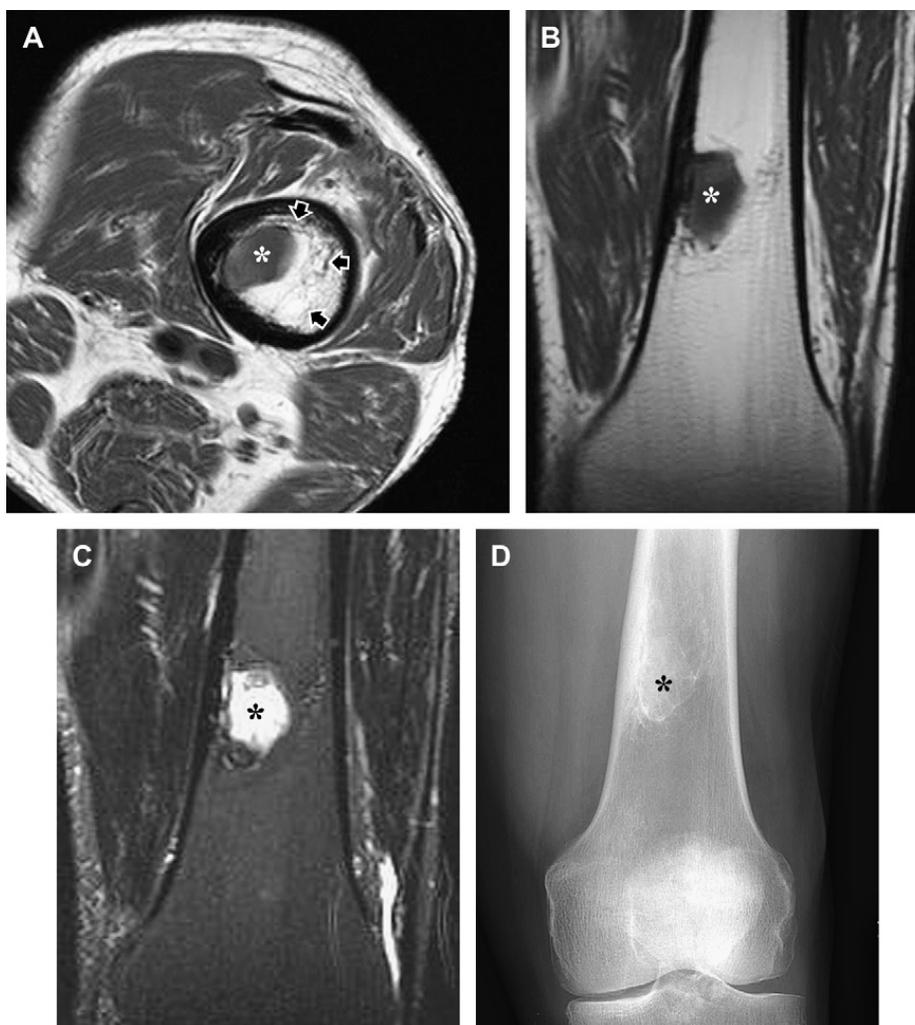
Intraosseous lipoma with involutinal change in the distal femur of a 72-year-old woman. (A) Axial T1-weighted (TR/TE; 623/17) spin-echo MR image of the distal femur shows an area of cyst formation (asterisk) within the lesion. Portions of the lesion are well delineated by marginal sclerosis (arrows), whereas other areas are poorly defined. (B, C) Corresponding coronal T1-weighted (TR/TE; 620/17) (B) spin-echo and short-tau inversion recovery (TR/TE/TI; 7870/86/160) (C) MR images show the involutinal cyst (asterisk), although the margins are incompletely visualized. (D) Anteroposterior radiograph of the distal femur shows a thin mineralized margin around the cyst (asterisk). Portions of the mineralized margin around the lesion are also visualized.
